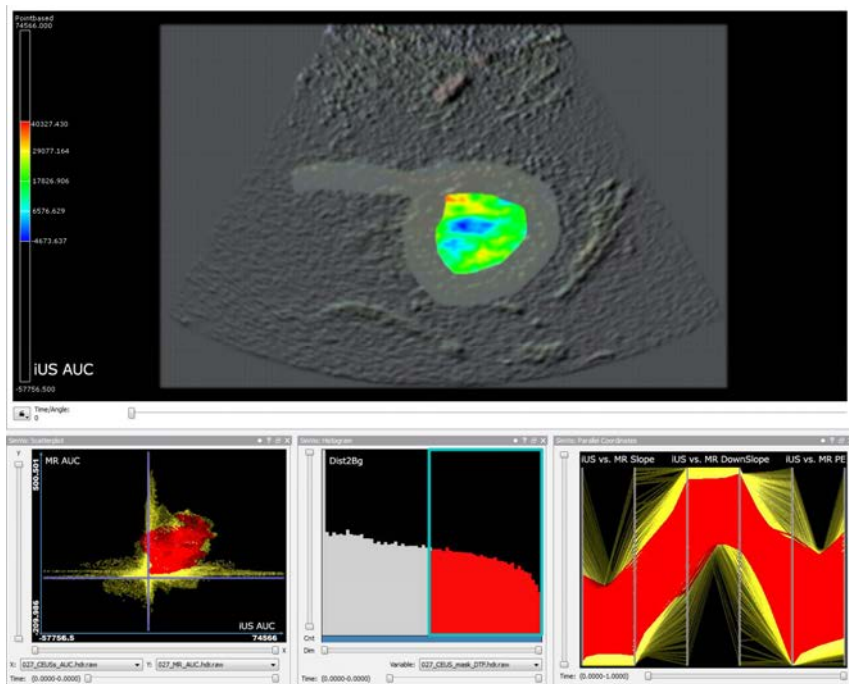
Concurrent, interactive visual analysis of perfusion parameters derived from intraoperative contrast-enhanced Ultrasound data (iUS) and preoperative MR perfusion data. The user may select an interesting range of parameter values within one or more of the attribute views (lower row) causing a colored emphasis of the associated tumor part in the spatial view (upper row).
